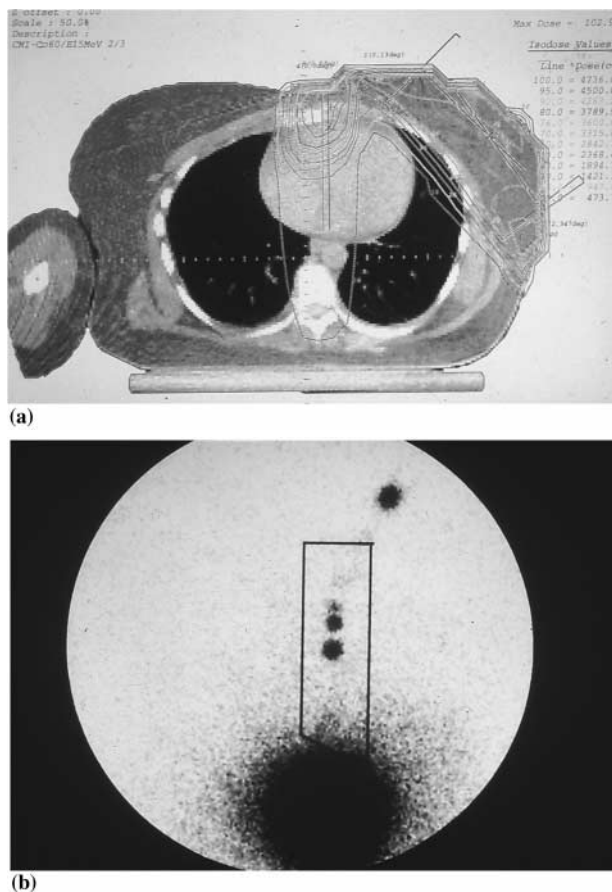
a) Tangential radiation fields to treat the breast and chest wall and a direct mixed beam with 60% of 9 MeV electrons and 40% of Co60 photons. Radiation isodoses are displayed in one CT-scan slice. The anterior part of the heart receives a total radiation dose of less than 26 Gy in 5 weeks. b) To help the determination of depth and location of the IMC; an IMC scintigraphy was performed previously.
